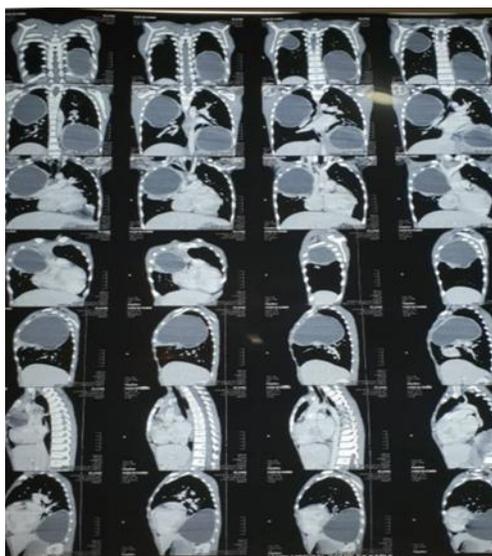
Chest CT scan showing bilateral lung hydatidic cysts.
